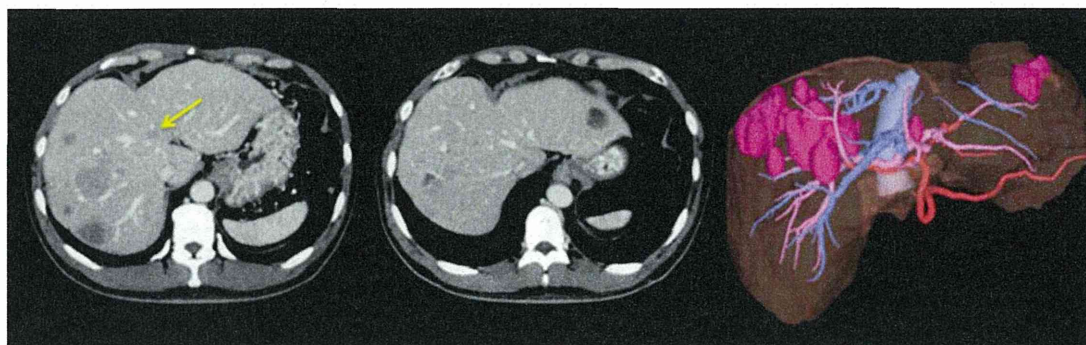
CT images of multiple hepatic carcinoid tumors treated by hybrid resection, and a lesion treated by radiofrequency ablation (*arrow*). The *right panel* is a 3D reconstructed image made from CT scans obtained by a Synapse Vincent instrument (Fujifilm Medical, Tokyo, Japan)
